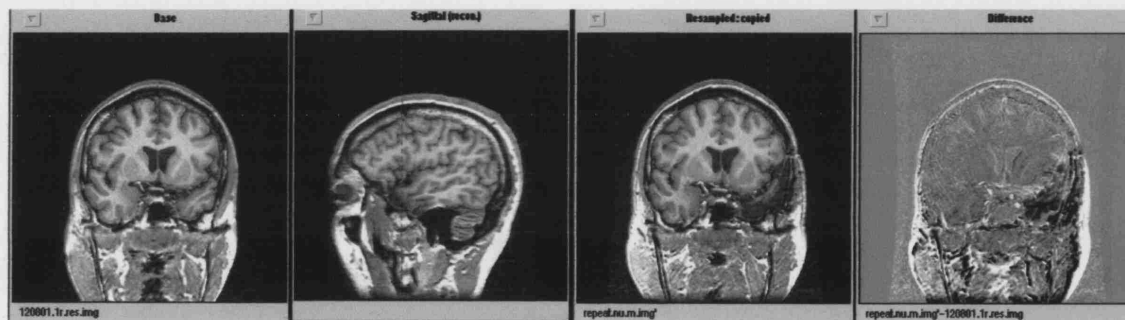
MR images from patient A12, showing the pre- and post-surgical images described in the text.
